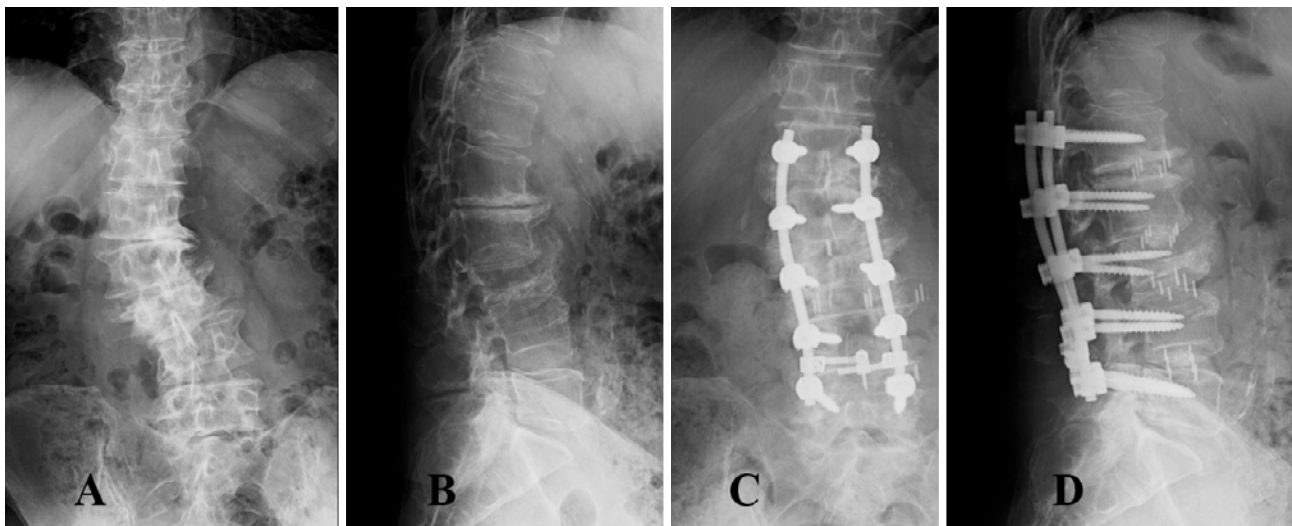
Preoperative radiographs of the lumbar spine showing degenerative kyphoscoliosis (A: anterior–posterior view; B: lateral view). Postoperative radiographs of the lumbar spine (C: anterior–posterior view; D: lateral view).
